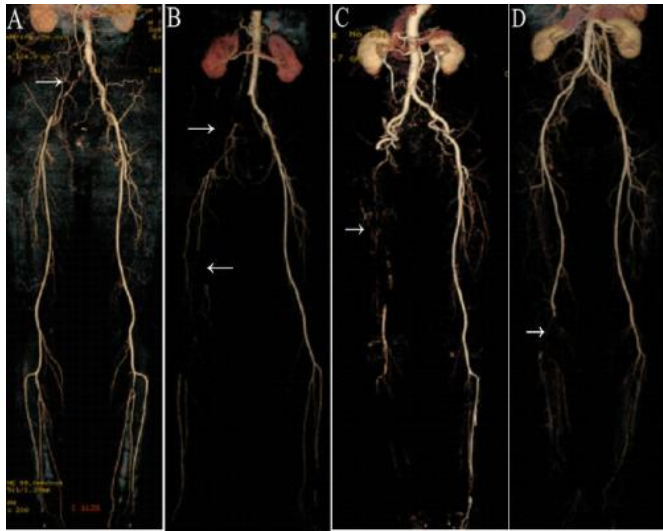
CTA reconstruction of ALI. The different position of arterial thrombosis in APS-ALI. A: iliac artery thrombosis; B: iliofemoral artery thrombosis; C: femoral artery thrombosis; D: popliteal/below-knee artery thrombosis; There was no obvious atherosclerosis in lower limb artery. (CTA: computed tomography angiography; APS: antiphospholipid syndrome; ALI: acute lower limb ischemia)
